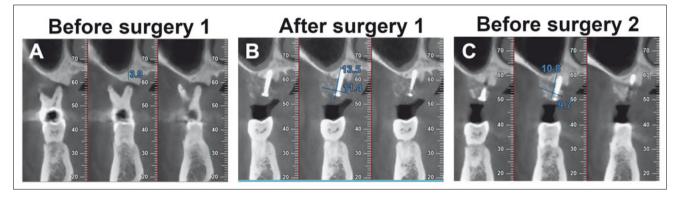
CBCT showing the changes of the vertical bone height. (A) The less-optimistic periodontal situation of tooth 16, with an available bone height < 4 mm. (B) Situation following extraction of tooth 16 and bone augmentation 2 weeks later. (C) After 5 months of healing, the increased density indicating new bone formation in grafted area with rhBMP-2.
